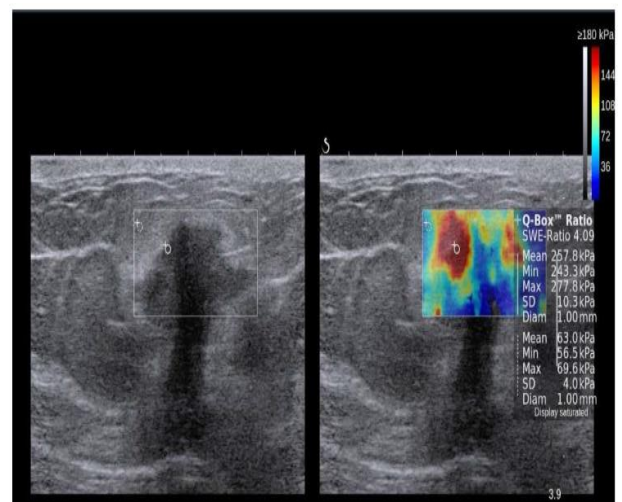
breast Ultrasound elastography image [57]
